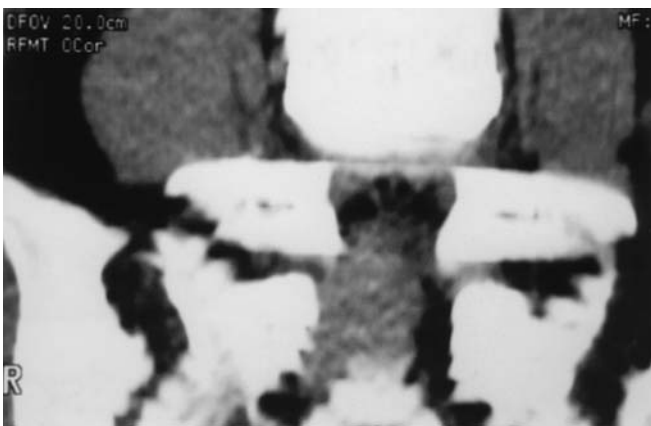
Oblique coronal contrast-enhanced CT. There is a downward extension of predominantly right-sided lumbosacral mass into a normal-sized right S2 neural foramen
